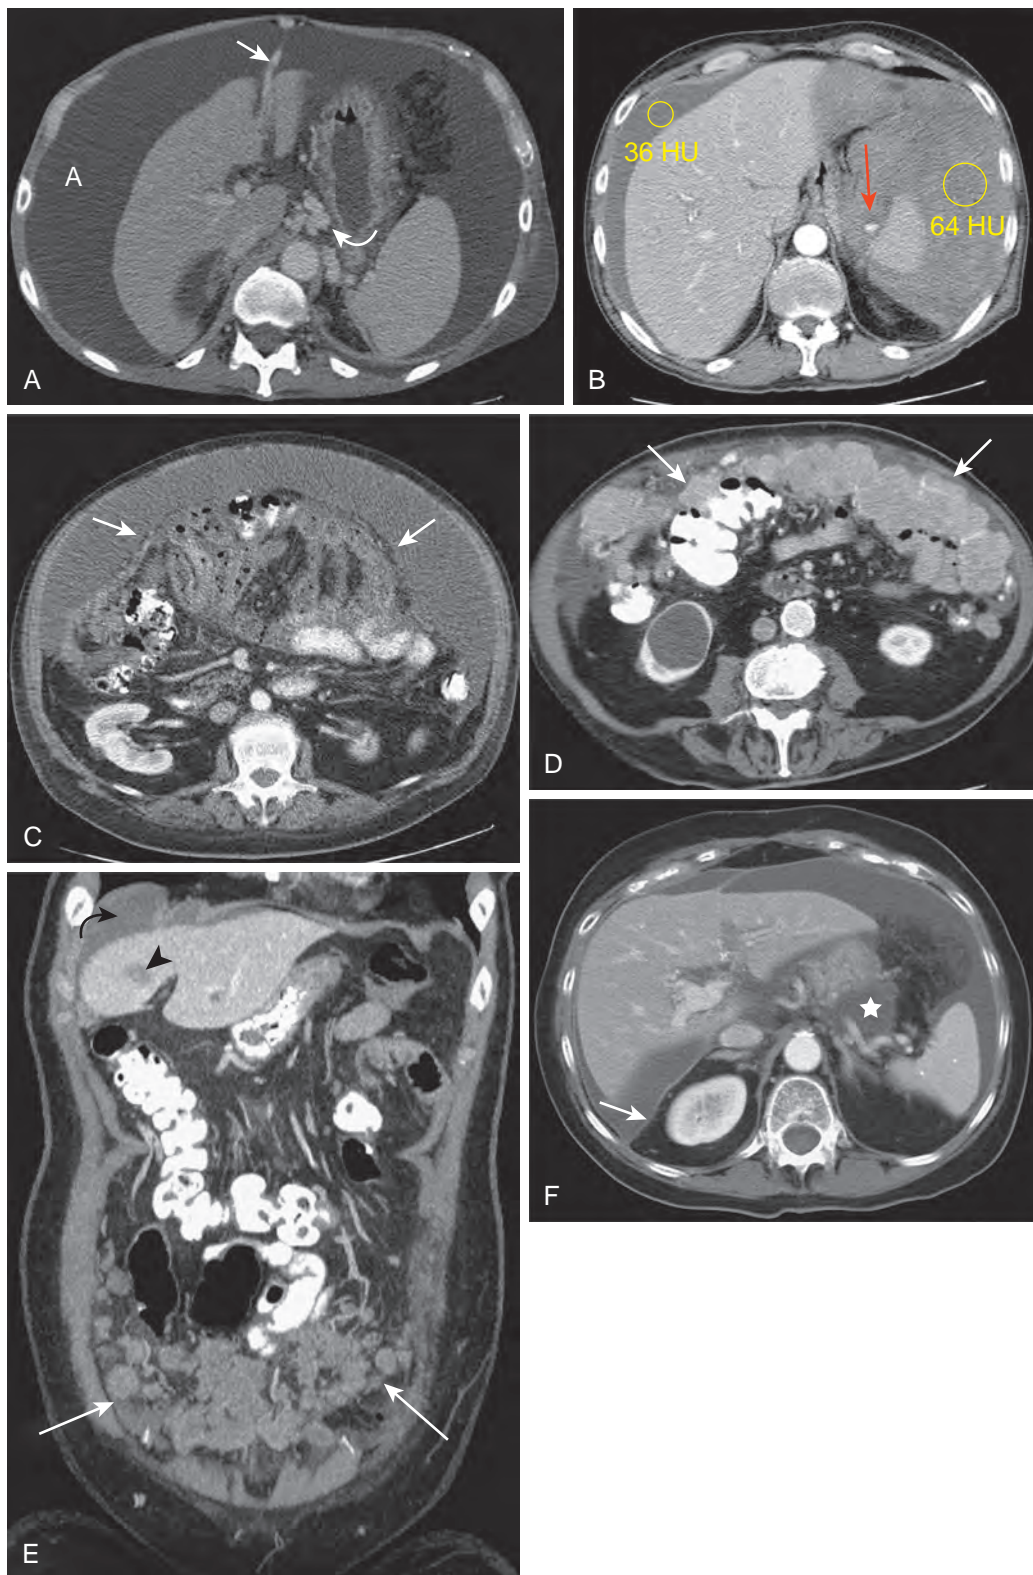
Ascites: CT features. A. Benign, transudative ascites (A) in a patient with cirrhosis and portal hypertension. A recanalized umbilical vein (*straight arrow*) and varices in the gastrohepatic ligament (*curved arrow*) can be seen. B. Hemoperitoneum and the sentinel clot sign are demonstrated in a patient with splenic trauma and active extravasation of contrast material (*arrow*). Note the higher density peritoneal fluid adjacent to the spleen (64 HU) and lower density fluid (36 HU) adjacent to the liver. C. Complicated ascites from an infection or tumor can cause retraction and a stellate appearance (*arrows*) of the mesentery. This patient had carcinomatosis from colon cancer. D. CT of a patient with ovarian cancer shows fluid associated with an omental cake (*arrows*), indicating carcinomatosis. The omental cake is caused by complete replacement of the omental fat by tumor. E. Coronal multiplanar reconstruction image shows omental cake (*straight arrows*), liver metastases (*arrowhead*), and ascites (*curved arrow*) in a patient with metastatic colon cancer. F. Fluid is identified in the lesser sac (*star*) and the greater peritoneal cavity. This finding and the abnormal enhancement and thickening of the peritoneum (*arrow*) suggest carcinomatosis in this patient with ovarian cancer.
